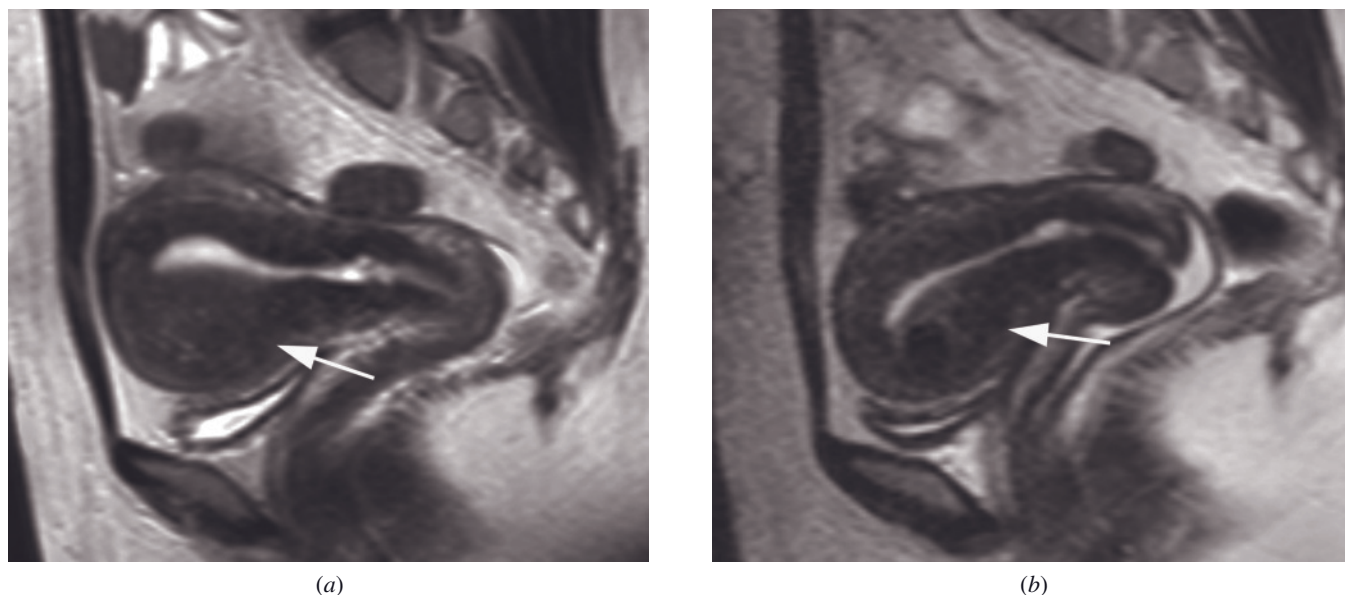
Adenomyosis before and after uterine artery embolization. Sagittal T2-weighted ETSE images before (*a*) and 9 months after (*b*) uterine artery embolization (UAE) show an adenomyoma (arrow, *a*) that decreases in size after UAE (arrow, *b*). There are reports of successful treatment of adenomyosis with UAE, although consistent long-term efficacy has not been established. (Courtesy of Claude Sirlin, M.D., University of California, San Diego).
